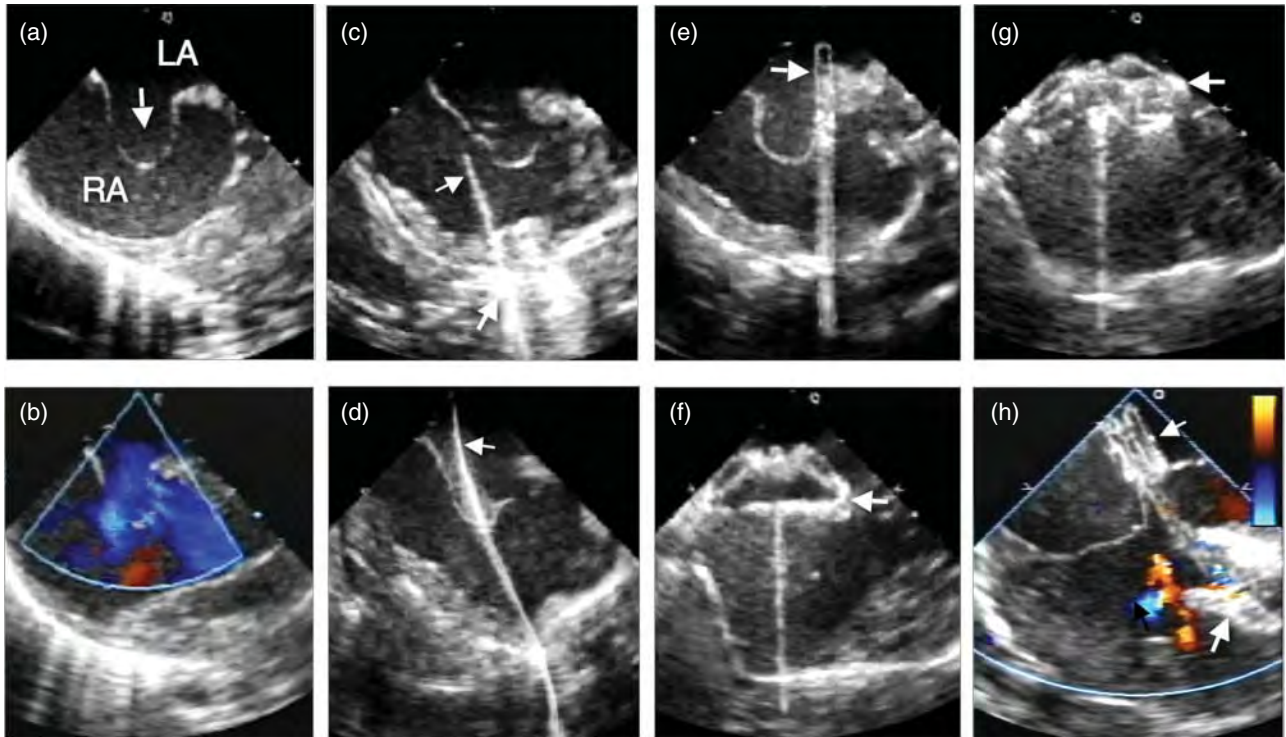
(a) TEE showing aneurysmal IAS bulging into RA. (b) Color flow Doppler across IAS showing fenestrated septum with left to right shunt. (c) Transatrial wire crossing the RA wall into RA. (d) Wire crossing the IAS into LA. (e) Delivery sheath crossing RA wall, passing through RA, IAS and into LA. (f) Delivery of LA disc. (g) Both discs have been delivered on both sides of the IAS. (h) Release of the device well-applied to the IAS and with no residual shunt.
